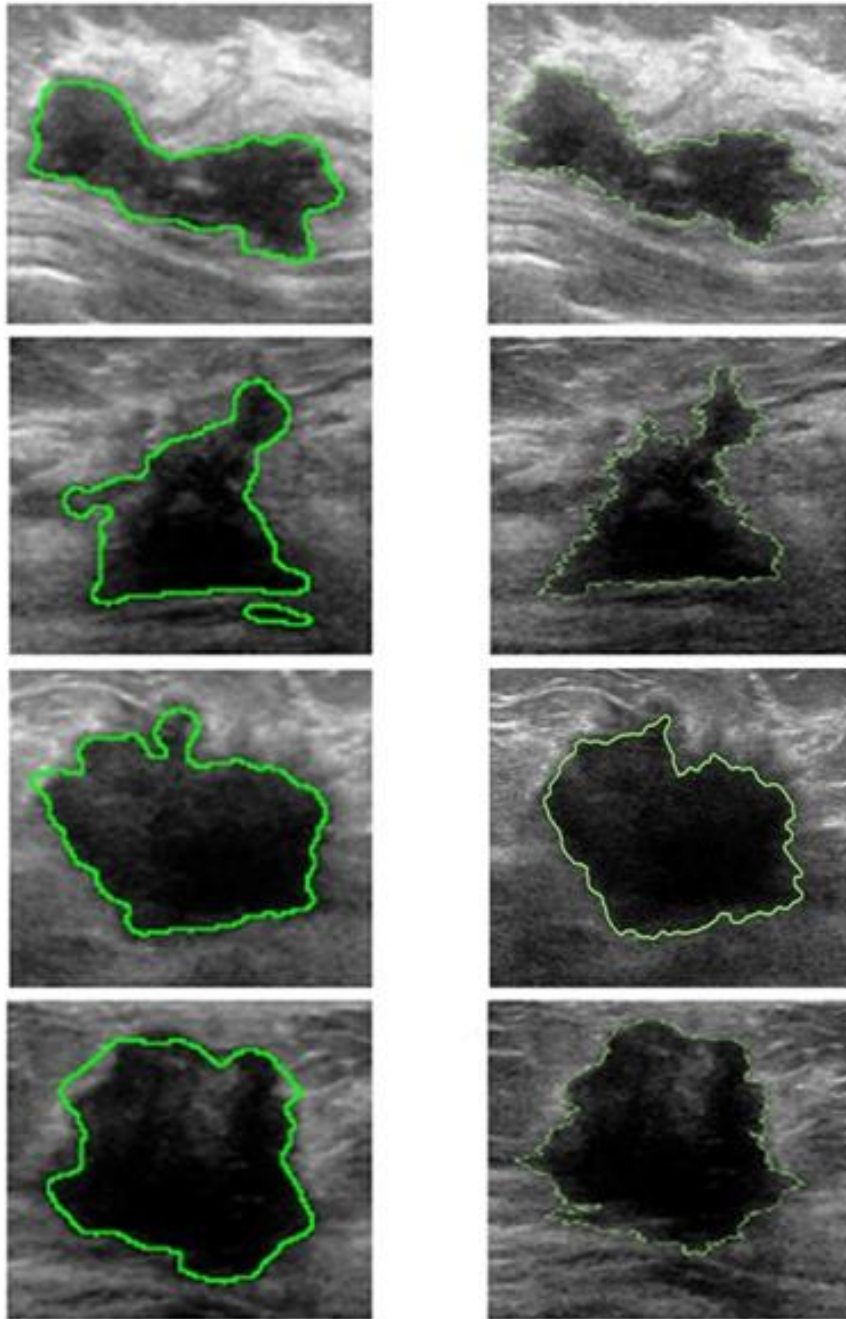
Segmentation of benign ultrasound breast image.
